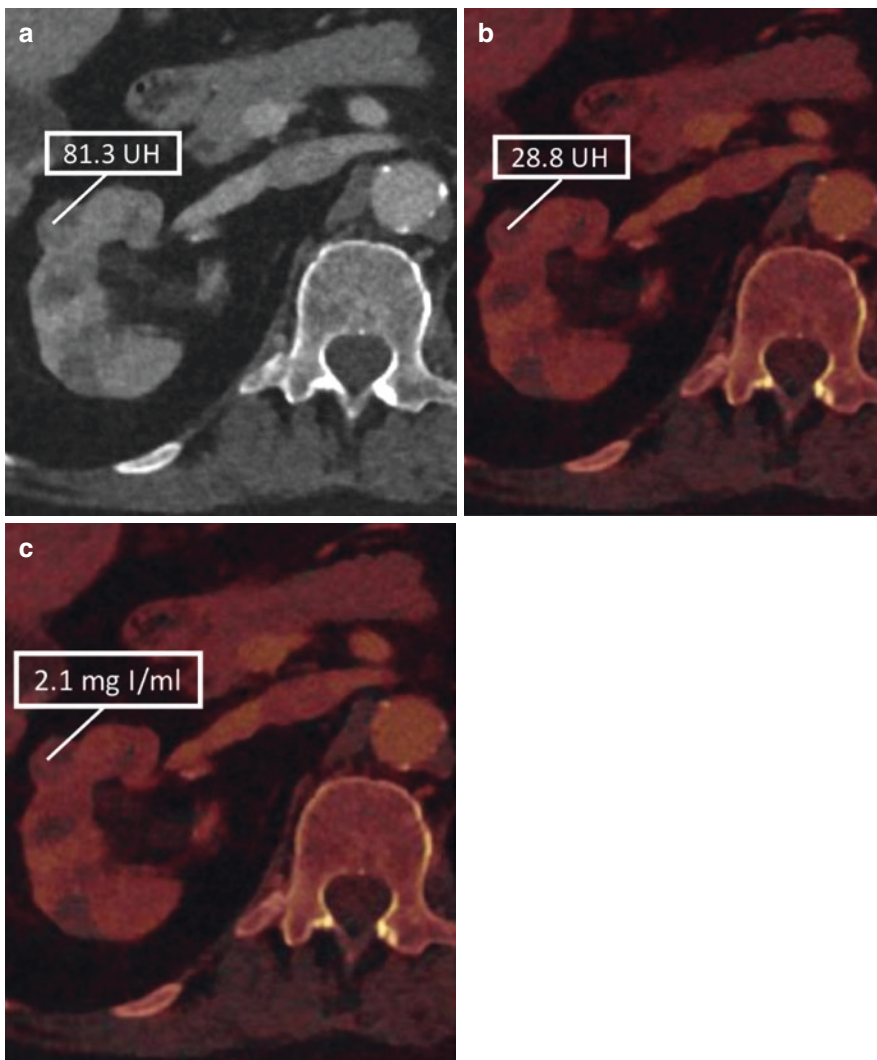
Blended 120-kVp (a), contrast map (b), and iodine material attenuation (c) CT images show a hypervascular lesion in the right kidney, with an iodine uptake of 1.4 mg I/ml, accurately classified as renal cell carcinoma
